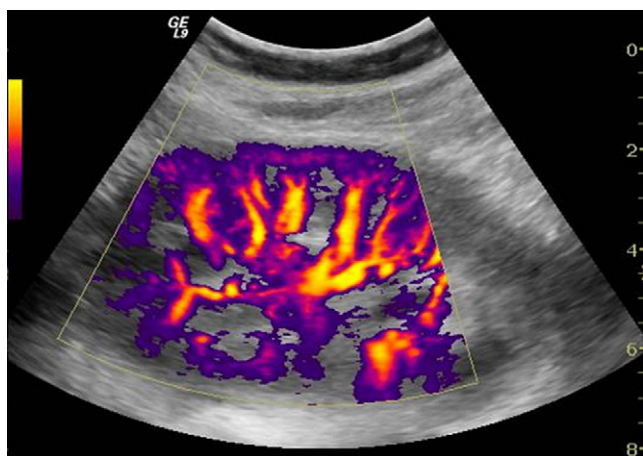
Coronal scan of the left kidney. Interlobar and interlobular segmental vessels. Perfusional cortical *blushing*, which is especially evident on power Doppler or *dynamic-flow* studies, consists of the appearance of a network of thin vessels that pulsate rhythmically with the systolic/diastolic expansions of the parenchymal vessels.
